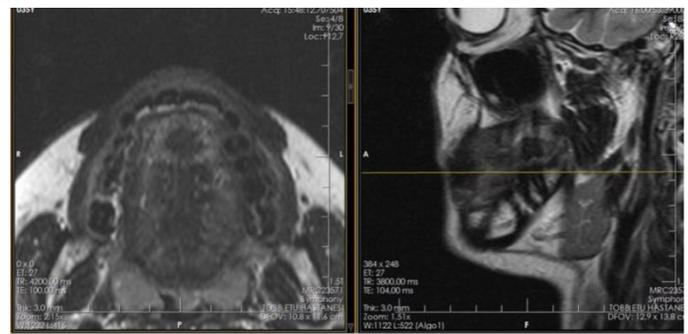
Magnetic resonance images of modiolus anguli oris at the corner of the mouth
